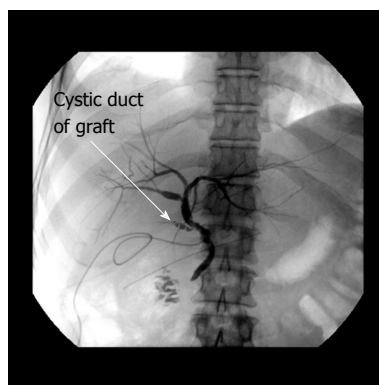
Normal anatomy of bile duct anastomosis (side-to-side): T-tube X-ray six weeks after liver transplantation.
